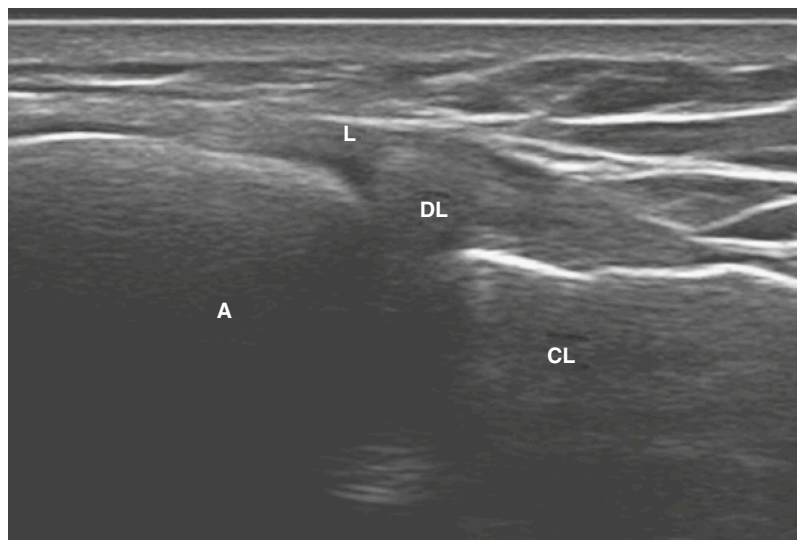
ACROMIOCLAVICULAR JOINT. Ultrasound shows the acromioclavicular joint. A, acromion; CL, clavicle; DL, interarticular disk; L, acromioclavicular ligament.
